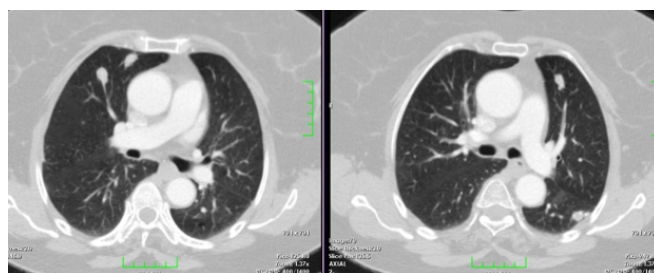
Postoperative thoracic CT showing stable lesions at 9th month follow up.
